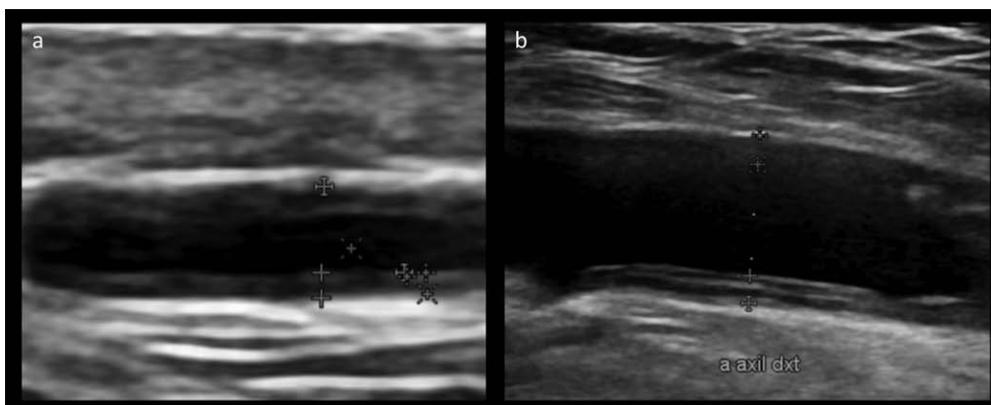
Ultrasound in the diagnosis of GCA: vascular ultrasound examination of large and medium-sized vessels can reveal a homogenous hypoechoic wall swelling in A) the superficial temporal artery and/or B) the axillary artery due to subclinical GCA in PMR patients.
